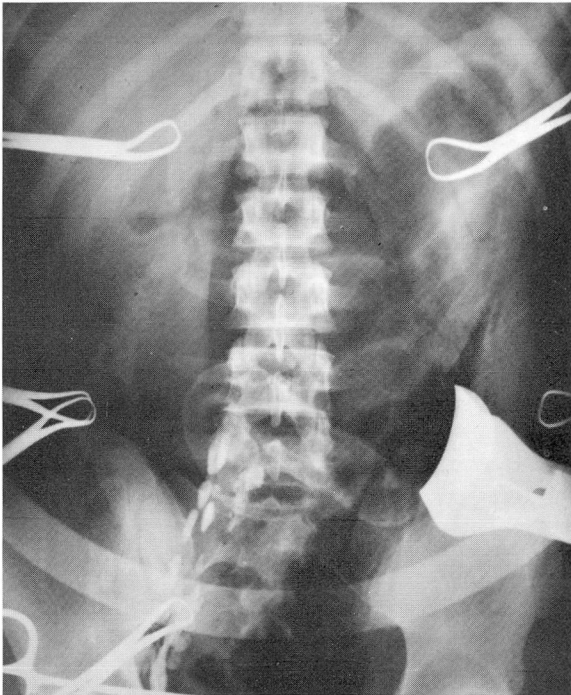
Case 1. An operative roentgenogram that shows the completeness of lymph node dissection.
